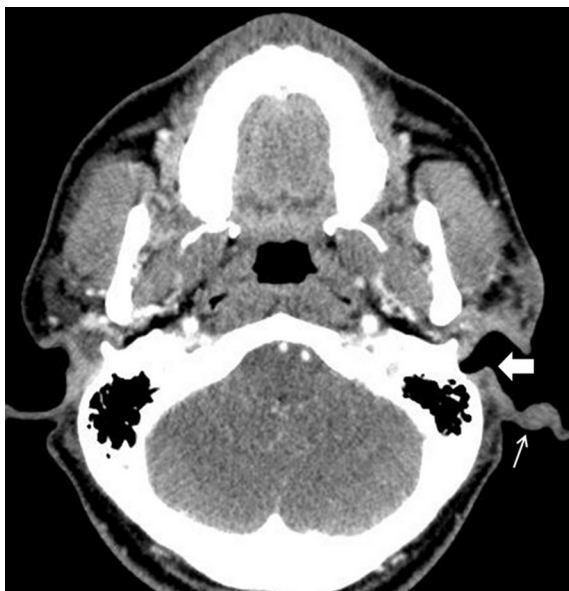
Computed tomography image showing a tumor involving the auricle (shallow arrow) and extending into the external auditory canal (thick arrow) in a patient with Kimura's disease. In this case, the commercially available bolus may not be suitable to enhance the dose to the ear cavity and auricle given their irregular anatomic structure.
